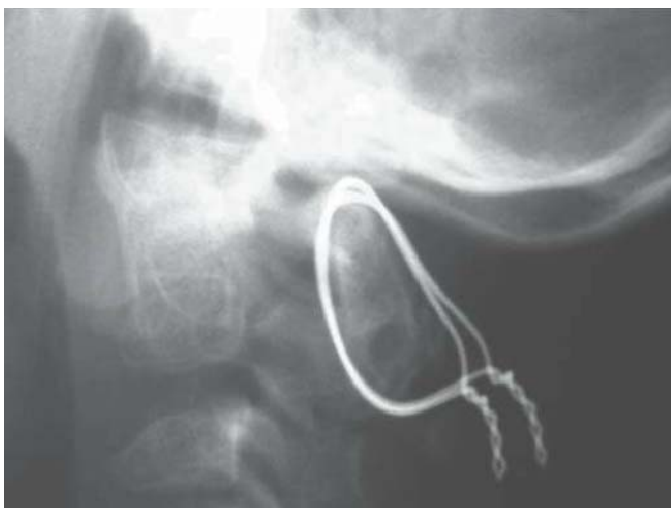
Radiograph of a 4-year-old with pseudoachondroplasia after cervical fusion and sublaminar wiring for cervical instability.
